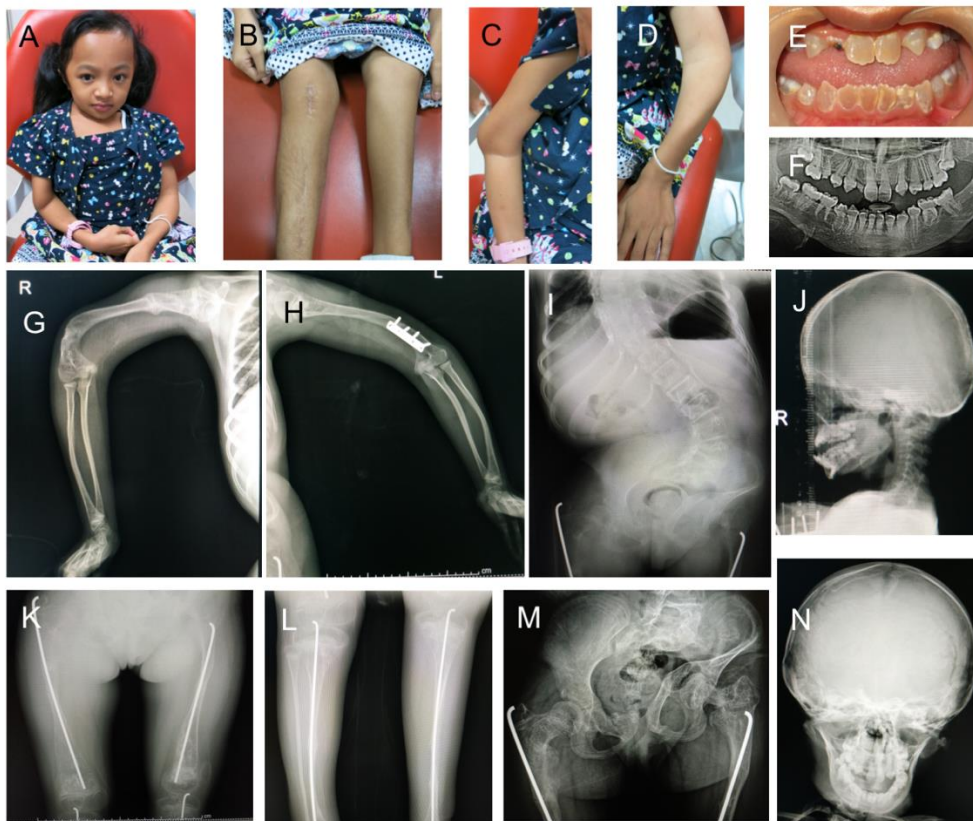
Clinical features associated with proband. The photographs and radiographs display the clinical phenotype of proband.
